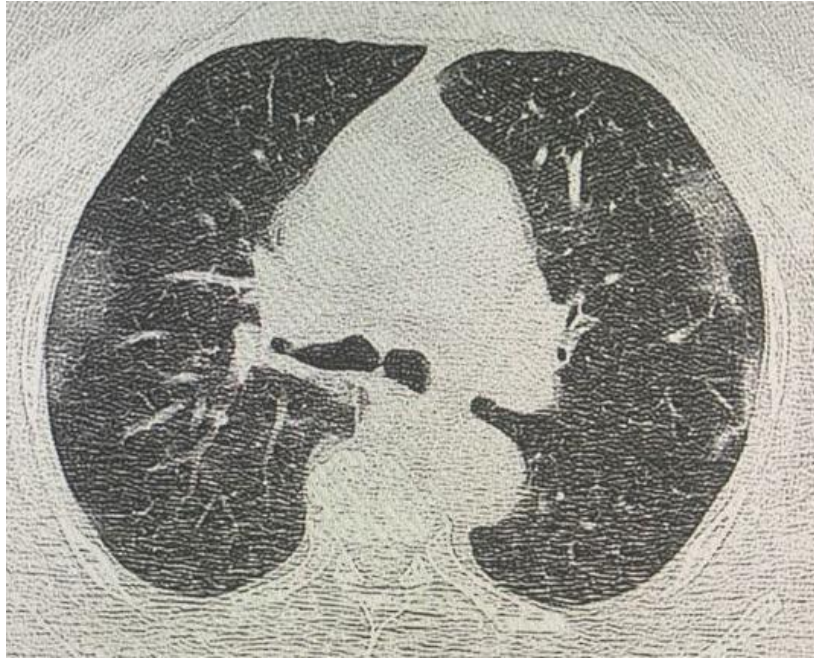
Axial HRCT Chest image in 51 years old male shows the mixed pattern of opacification (ground glass opacity admixed with consolidation) seen in bilateral lung fields distributed peripherally with CTSS 17.
